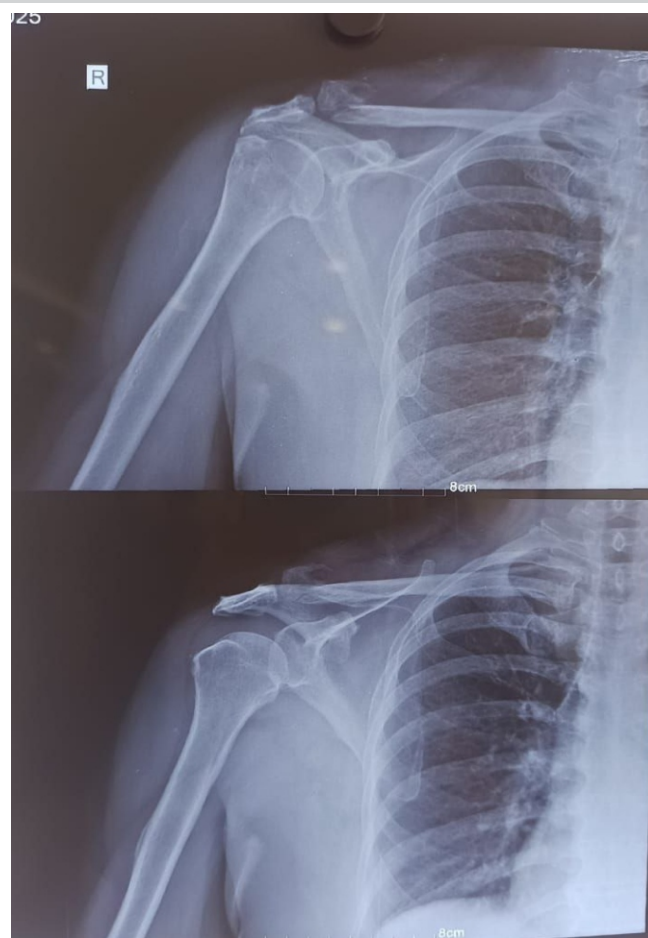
Pre-operative X-rays showing a bipolar clavicle fracture.
